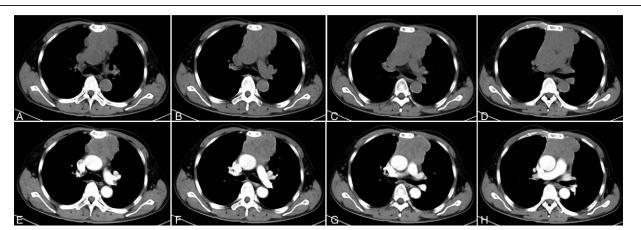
(A-H) Preoperative transverse computed tomography showing the primary thymic carcinoma in the anterior mediastinum.
